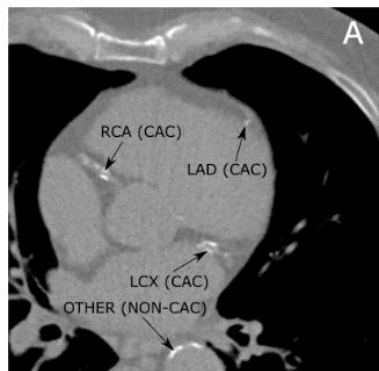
Calcified coronary plaques on noncontrast CT identified by arrows.
